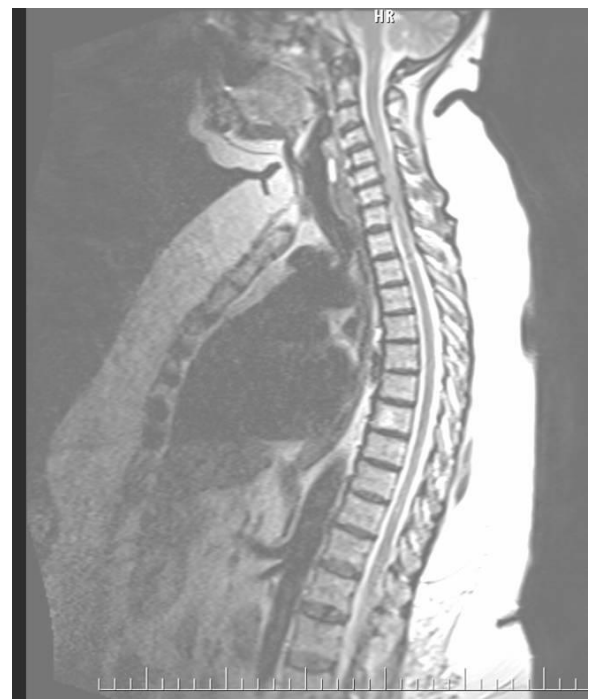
T2-weighted sagittal thoracolumbar MRI section shows that there wasn't an osteolytic lesion.
